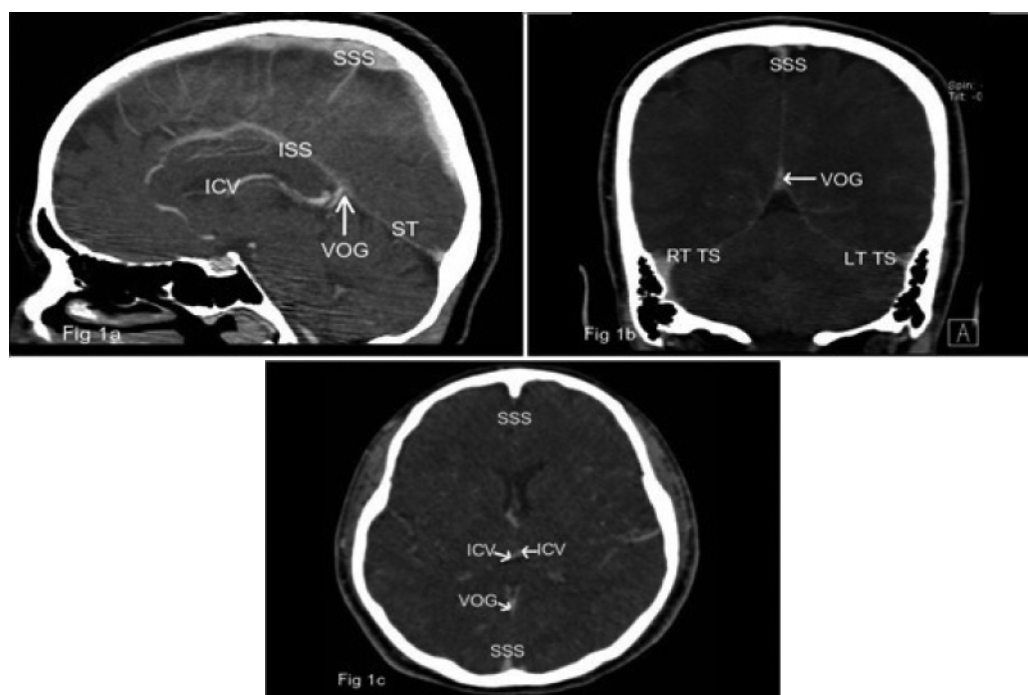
Contrast enhanced CT venogram (MDCTV) projected in multiplanar reformatted (MPR) images of the sagittal view (1a); coronal view (1b) and axial view (1c) showing normal anatomy of the cerebral veins and dural sinuses. SSS, superior sagittal sinus; ISS, inferior sagittal sinus; ICV, internal cerebral vein; VOG, vein of Galen; ST, straight sinus; RT, right, LT, left
